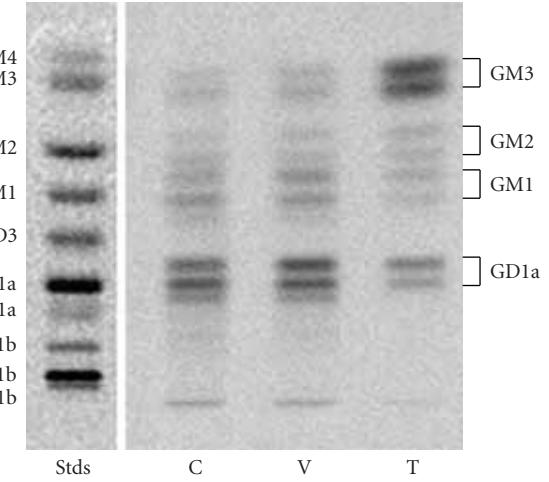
High-performance thin-layer chromatographic analysis of ganglioside distribution in the CT-2A astrocytoma: Control untransfected CT-2A (C), CT-2A transfected with empty vector alone (V), and CT-2A transfected with the antisense sequence to the *GalNAc-T* gene (T). Synthesized gangliosides appear as double bands due to ceramide structural heterogeneity. Analysis of synthesized gangliosides and standards (left lane) was as we described [7]. Knockdown of the *GalNAc-T* gene elevated GM3 content, while reducing GD1a content in the antisense T cells.
